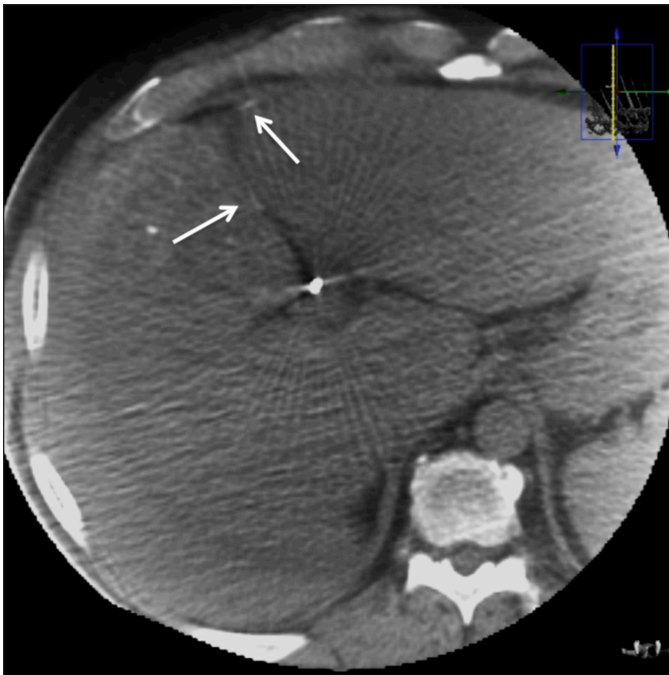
Immediate post procedure cone-beam CT image showing presence of hyperdense embolizing material (arrows) in the falciform ligament and coursing towards anterior abdominal wall consistent with course of the falciform artery.
